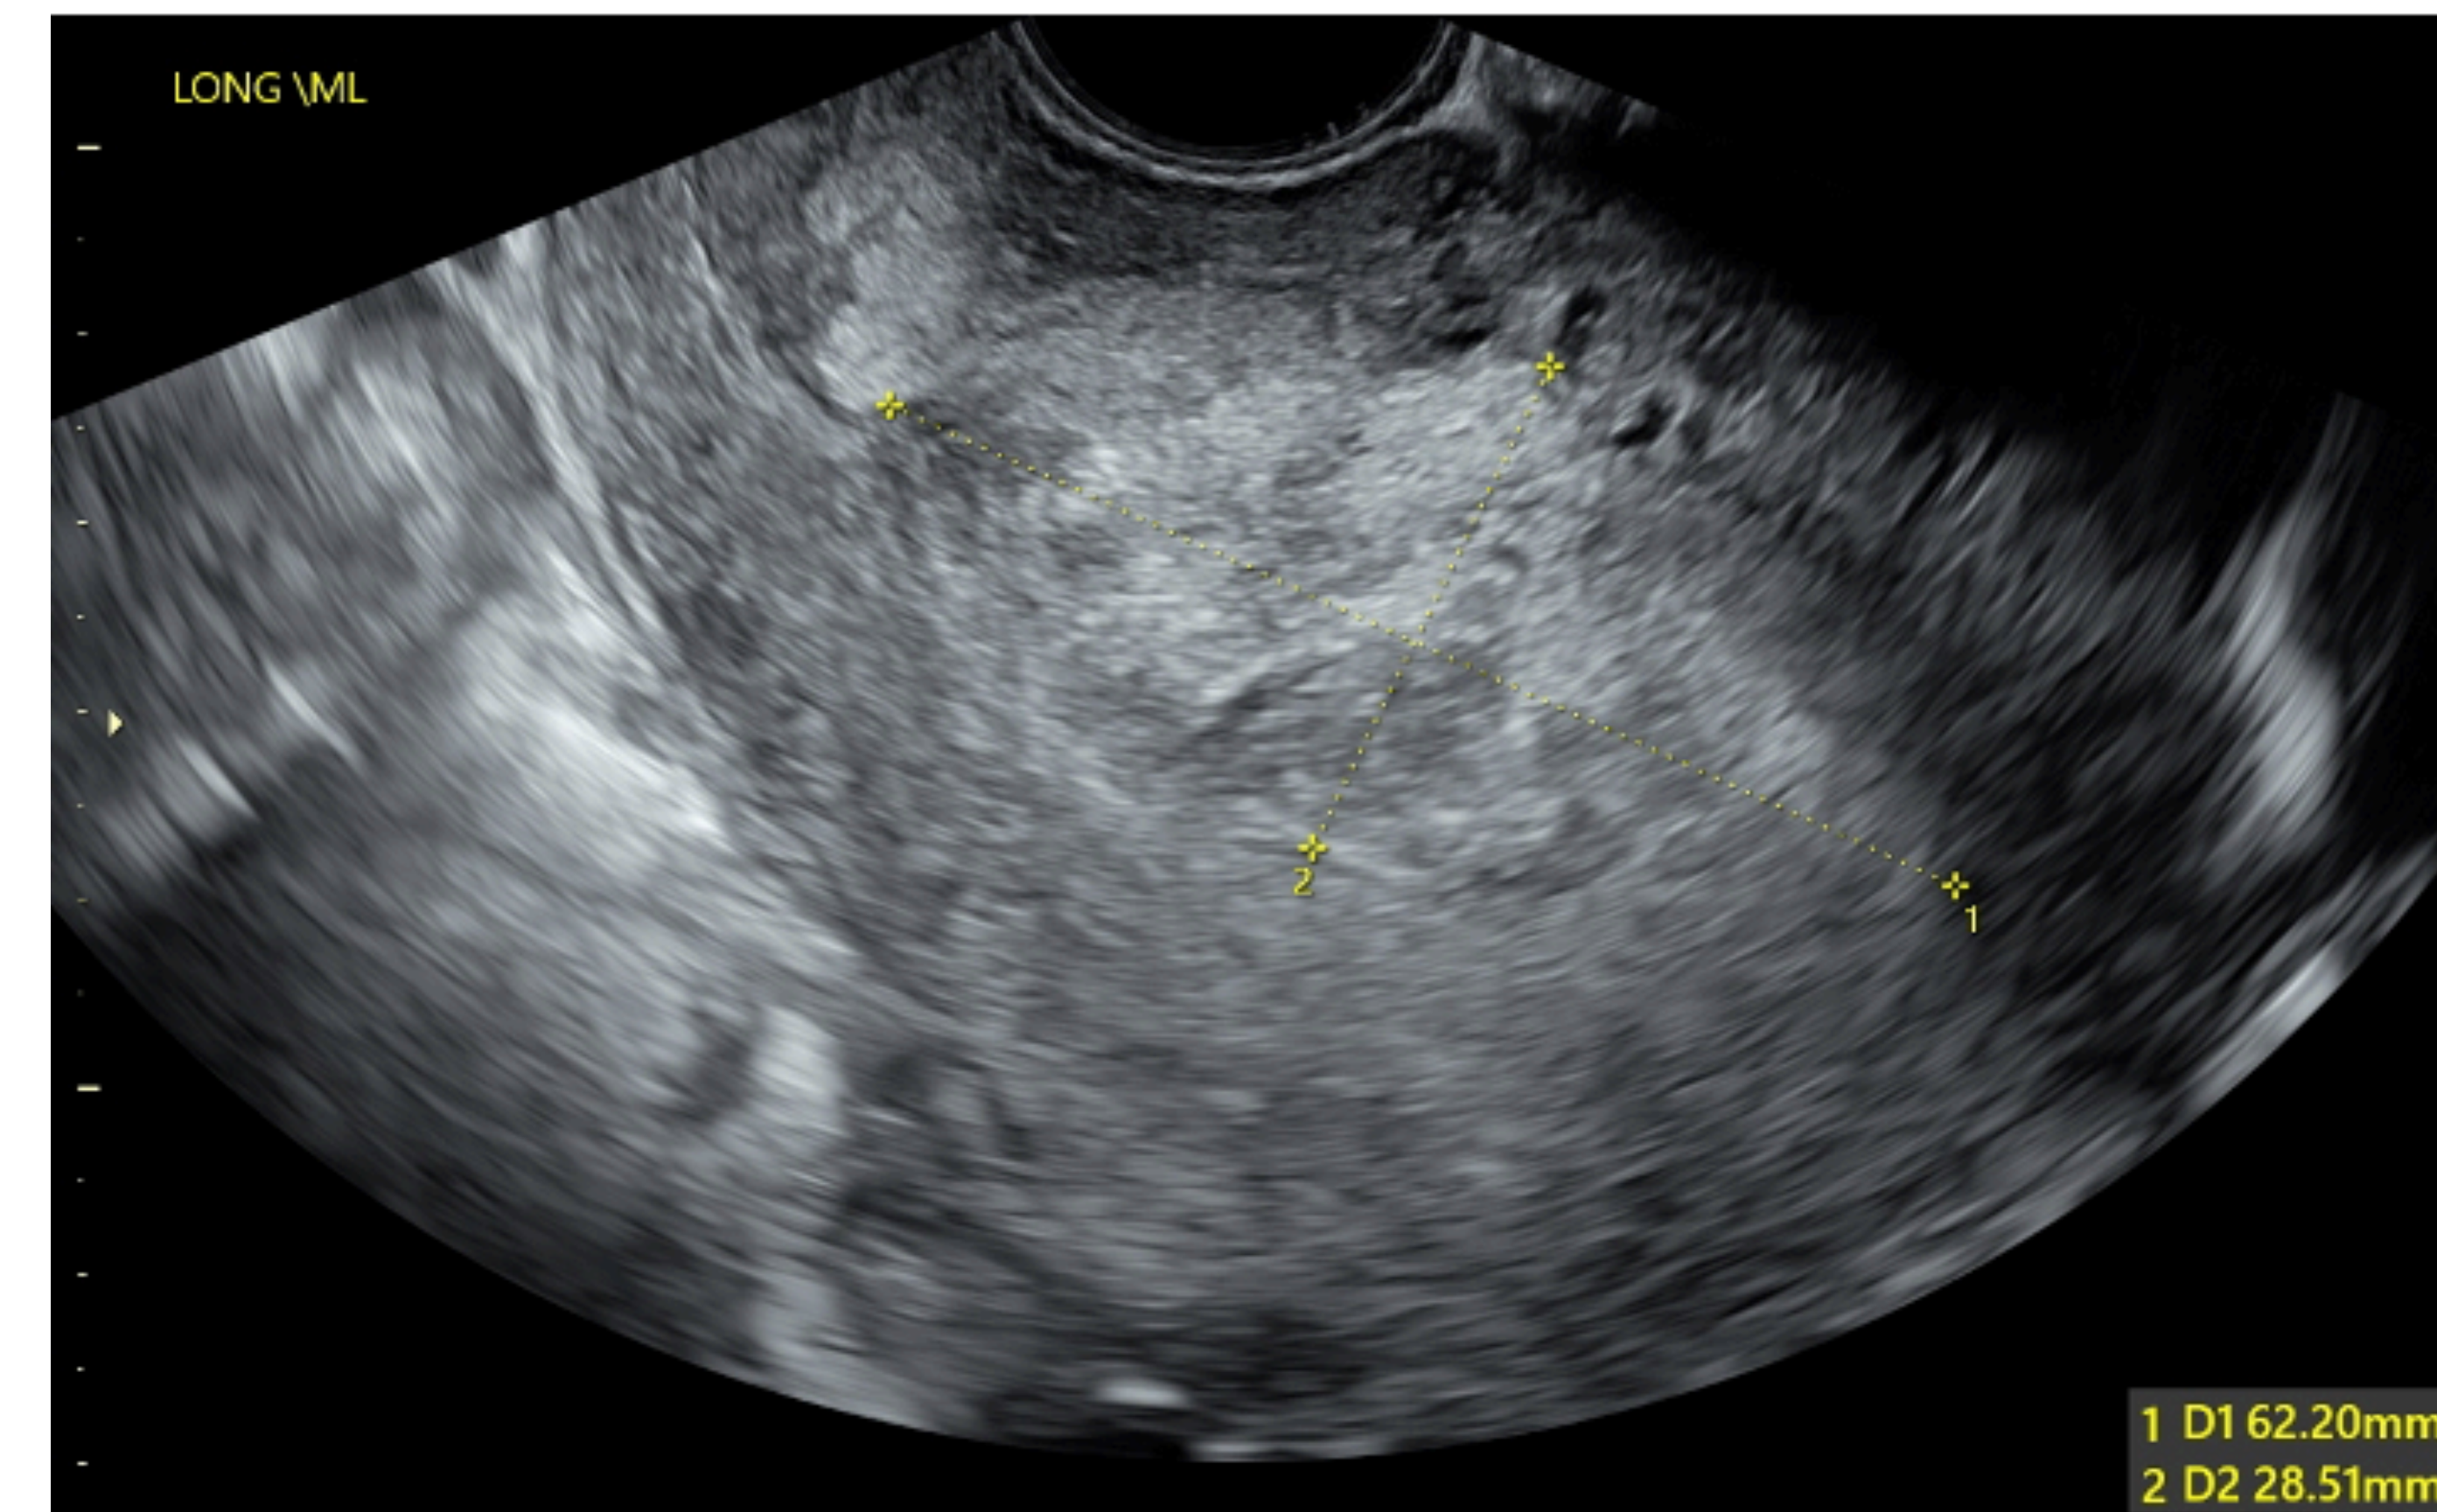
Pelvic ultrasound showing 62 x 29 x 44mm (40mL) heterogenous material.
